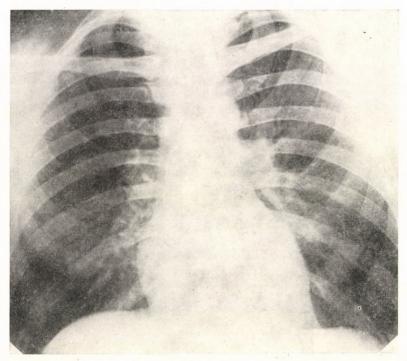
(Case 3). Chest X-rays. Typical polycythaemia vera syndrome with pulmonary fibrosis
